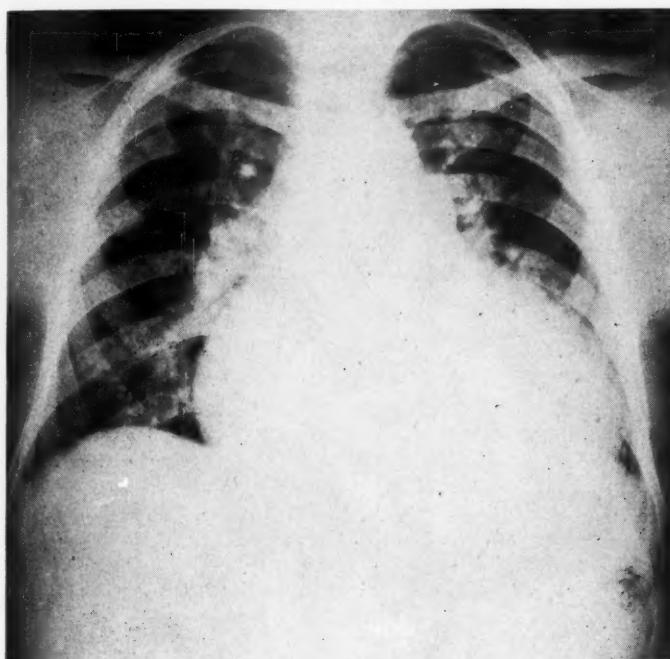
Roentgenogram of the thorax made October, 1944, showing extreme cardiac dilatation and passive congestion of the lungs.
